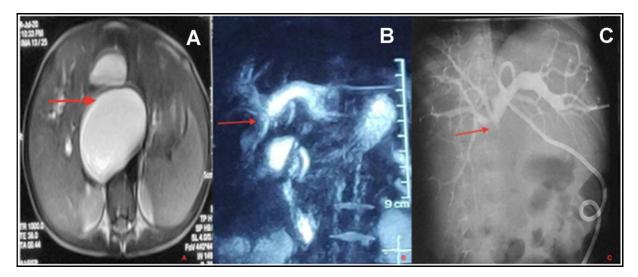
(A) T2 weighted axial magnetic resonance image showing a collection (arrow) along the surface of the liver. (B) Coronal MRCP (magnetic resonance cholangio-pancreatography) image showing dilated right and left biliary radicles (left > right) with abrupt cut-off (arrow) just beyond the primary confluence. (C) PTC (Percutaneous trans-hepatic cholangiogram) showing the opacification of dilated right and left biliary radicles (left > right) with no passage of contrast across the primary confluence (red arrow) into the common hepatic duct and the common bile duct.
